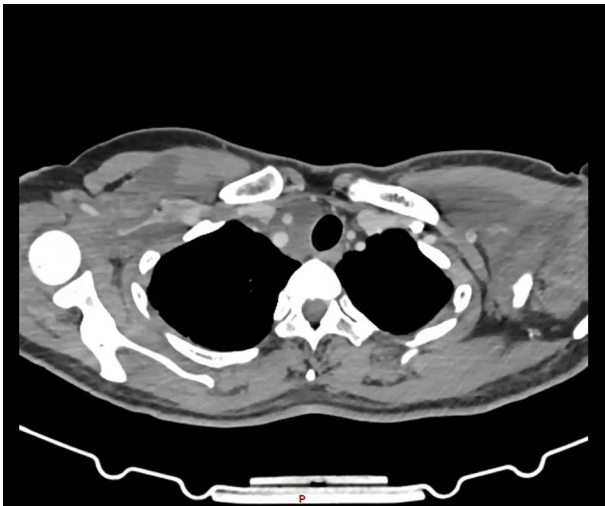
Computed tomography of the chest showing what appeared to be multiple enlarged and confluent mediastinal lymph nodes.
